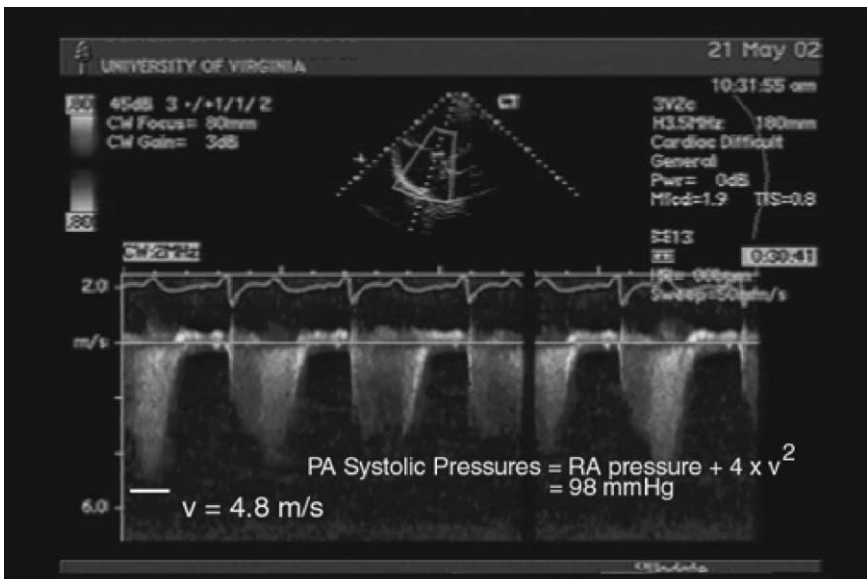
Doppler echocardiogram of a patient with pulmonary hypertension. Using the tricuspid regurgitation jet velocity and the modified Bernoulli equation, estimated pulmonary artery peak pressure is 98 mm Hg. This patient with CHD would not be eligible for competitive sports.
